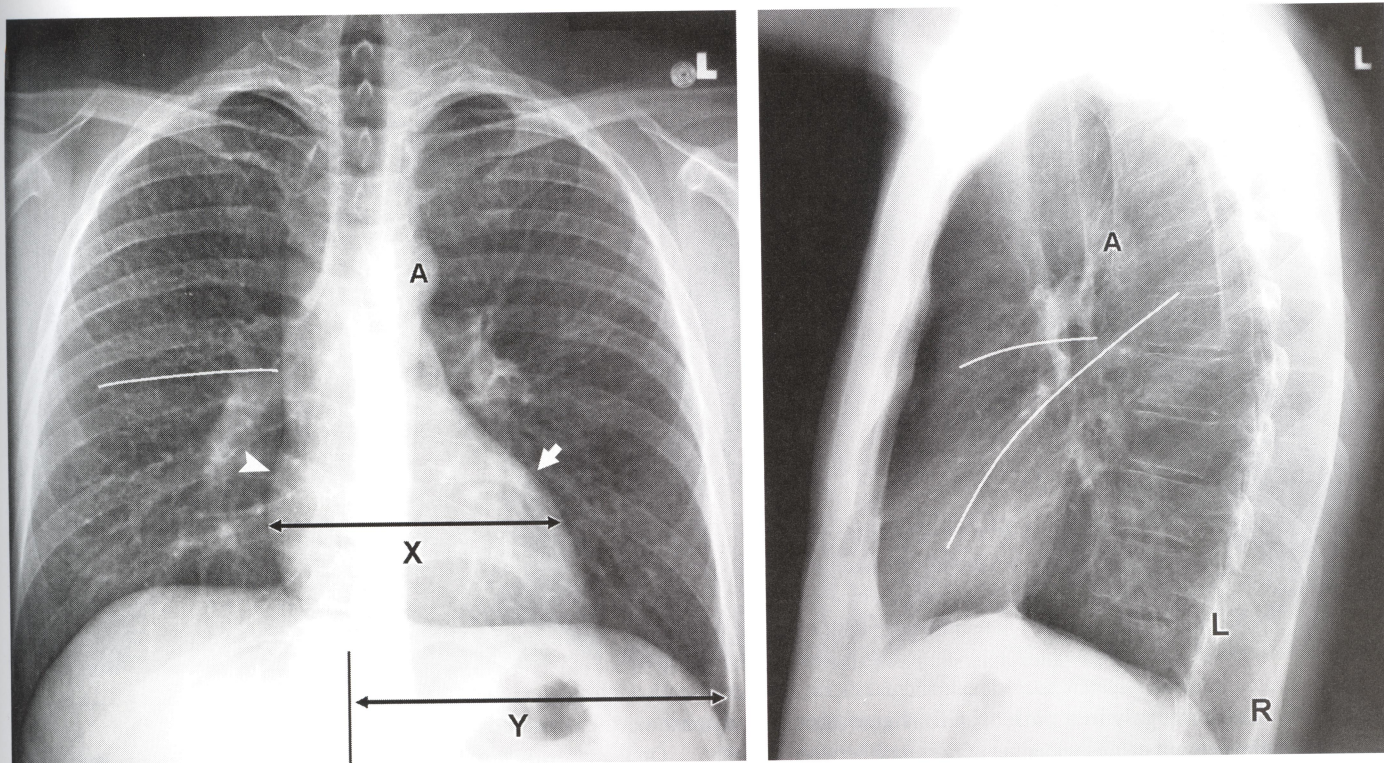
Normal PA and lateral radiographs in a young adult.
